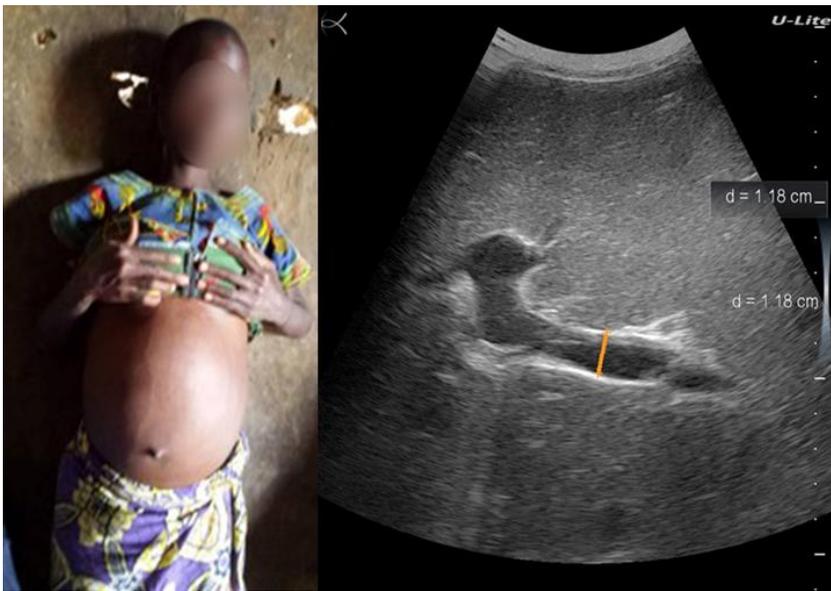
Patient #5 (left). Ultrasound examination (right) showed thickened periportal fibrosis and extended diameter of portal vein (orange bar).
